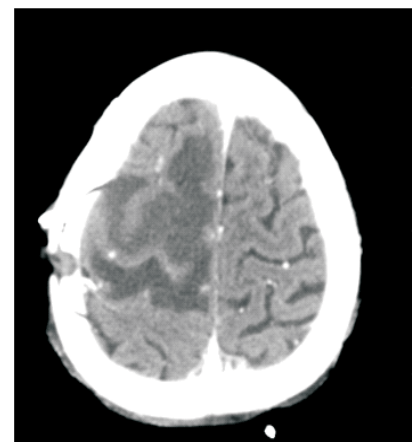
Postop CT head showing complete excision of lesion
